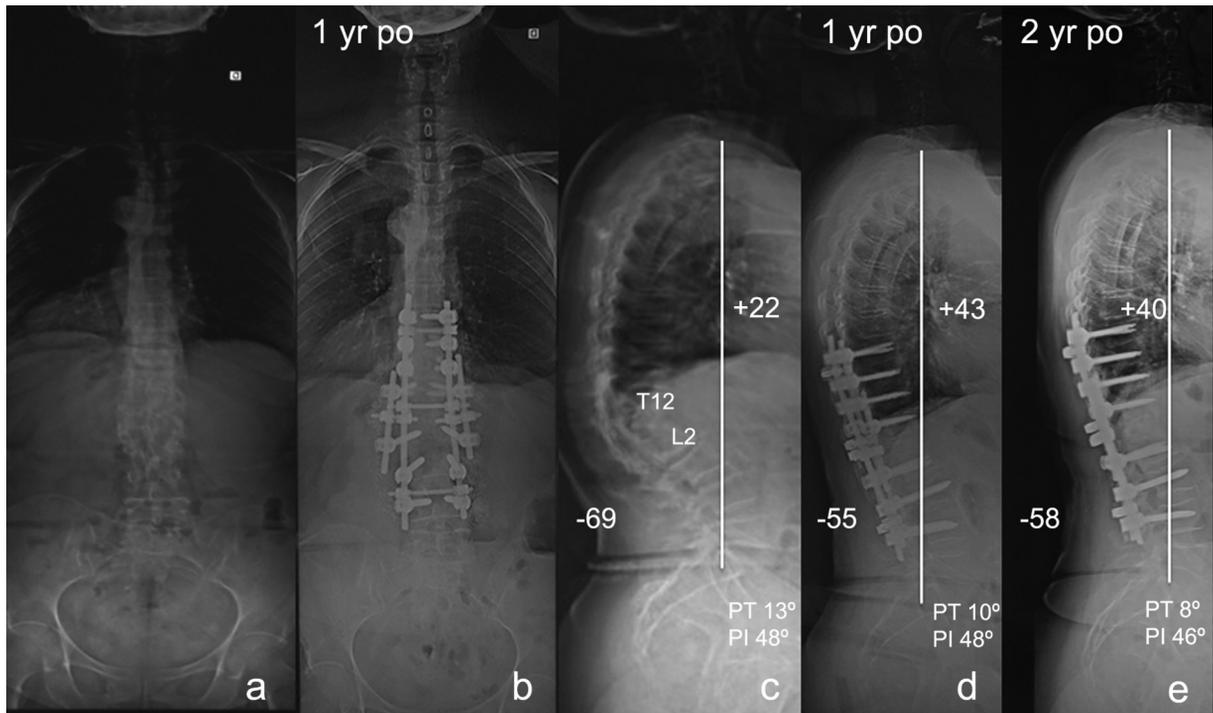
Preoperative standing radiographs (a and c) show short angular kyphosis with apex at L1 (Cobb angle: 34°) and normal sagittal vertical axis (SVA). After pedicle subtraction osteotomy (PSO) at L1 using 4-rod fixation, the thoracolumbar (TL) transition angle was restored (Cobb angle: 11° at the 2-year follow-up), and the compensatory thoracic hypokyphosis and lumbar hyperlordosis were solved.
